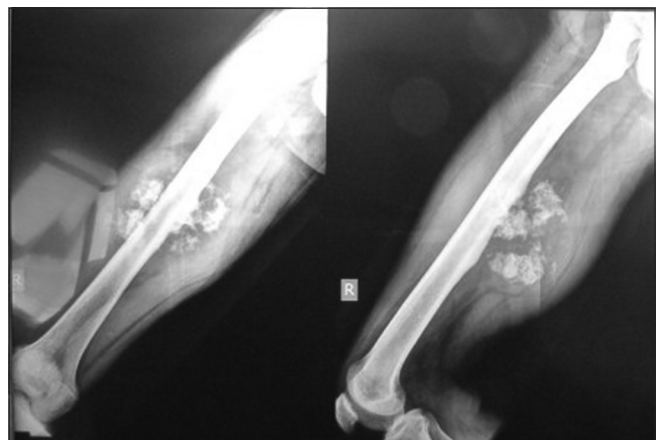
X-ray of the femur showing the tumour
